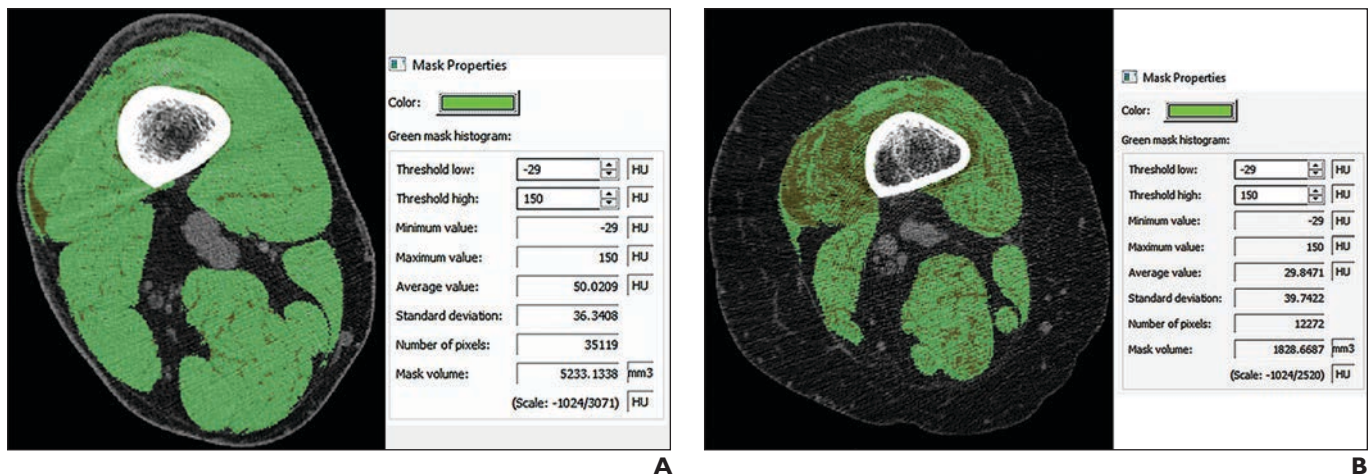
Images from opportunistic CT of muscle.
